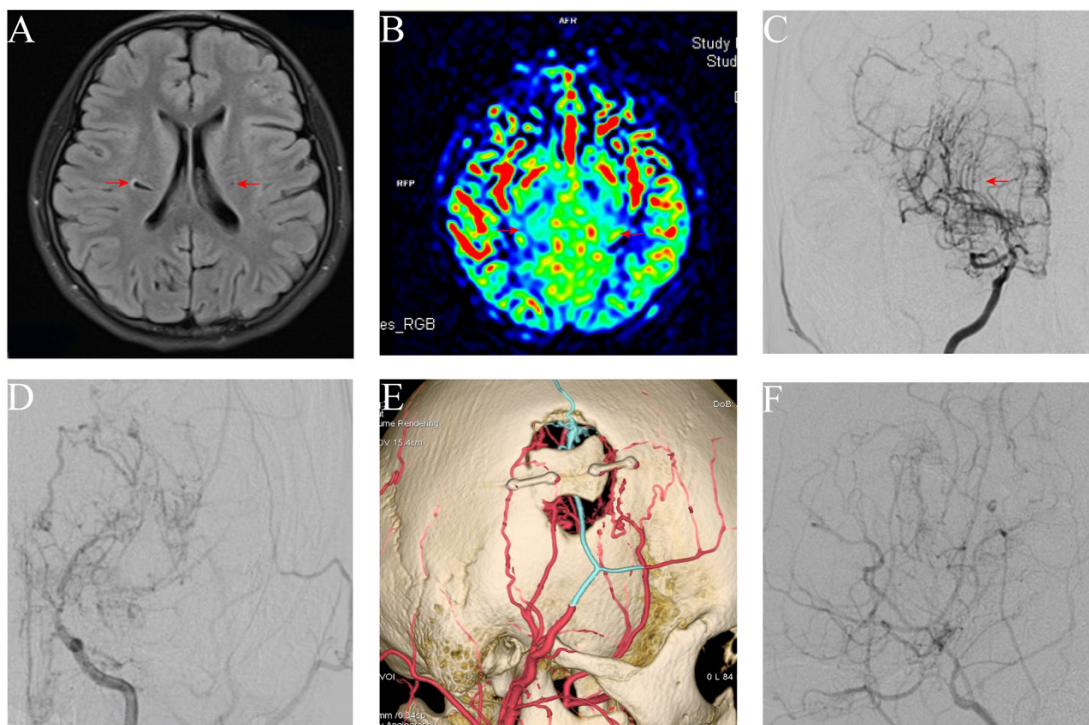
Image of Case 1. (A) Axial non-contrast MRI showing multiple punctate and patchy hyperintensities in the right basal ganglia and bilateral corona radiata. (B) Perfusion-weighted MRI demonstrating decreased bilateral cerebral blood flow perfusion. (C) An anteroposterior view of the right cerebral hemisphere angiogram before the procedure. (D) An anteroposterior view of the left cerebral hemisphere before the procedure. (E) Postoperative follow-up CTA. (F) Lateral view of the right cerebral hemisphere after EDAS procedure.
